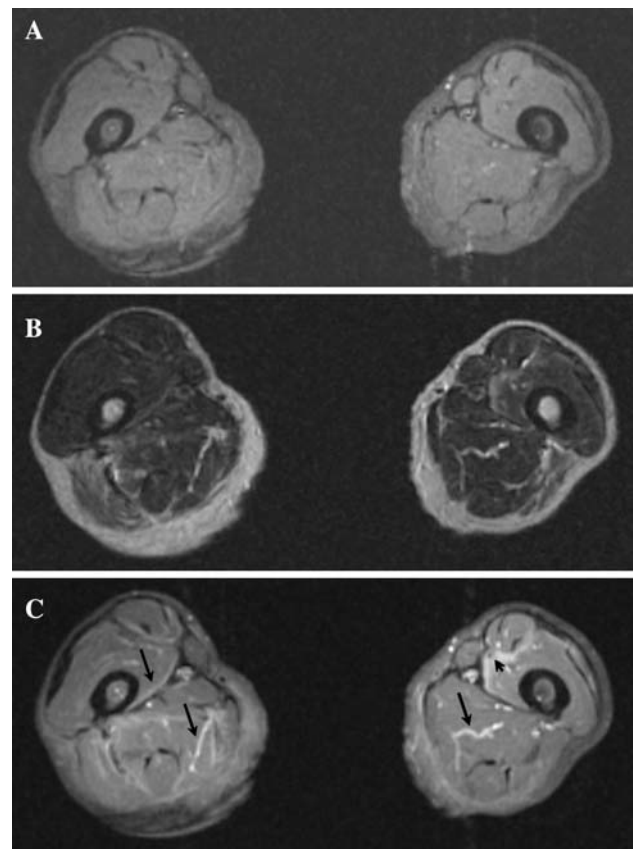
Thigh MRI in case 1 performed on day 3. a, b and c are T1-weighted, T2-weighted and gadolinium-enhanced T1-weighted axial images, respectively. In c, *arrows* depict contrast enhancement along the fascia, which is consistent with fasciitis. In c, the *arrowhead* shows contrast enhancement of not only the fascia, but also the muscle adjacent to the fascia. These findings are compatible with FPS
